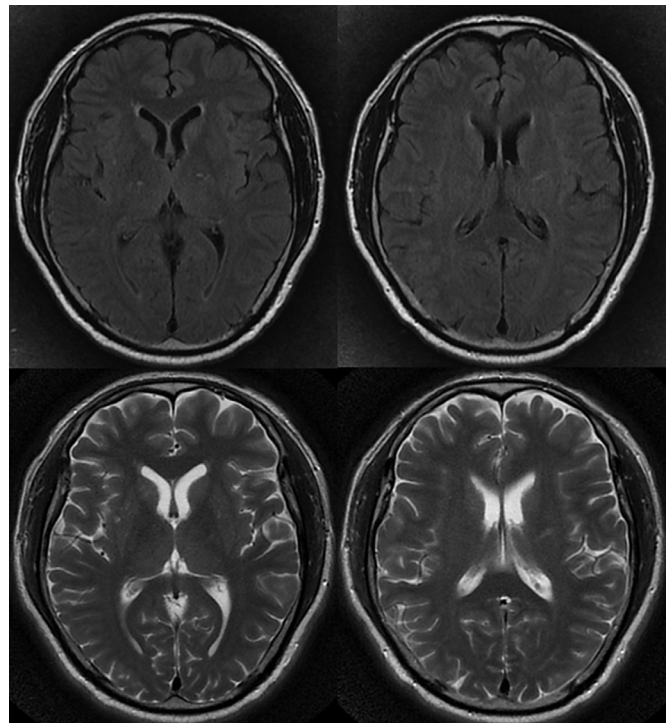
Brain magnetic resonance imaging showing small ischemic lesions located at basal ganglia and semiovale center on February 13, 2020 (Hospital day 16, Illness Day 20).
